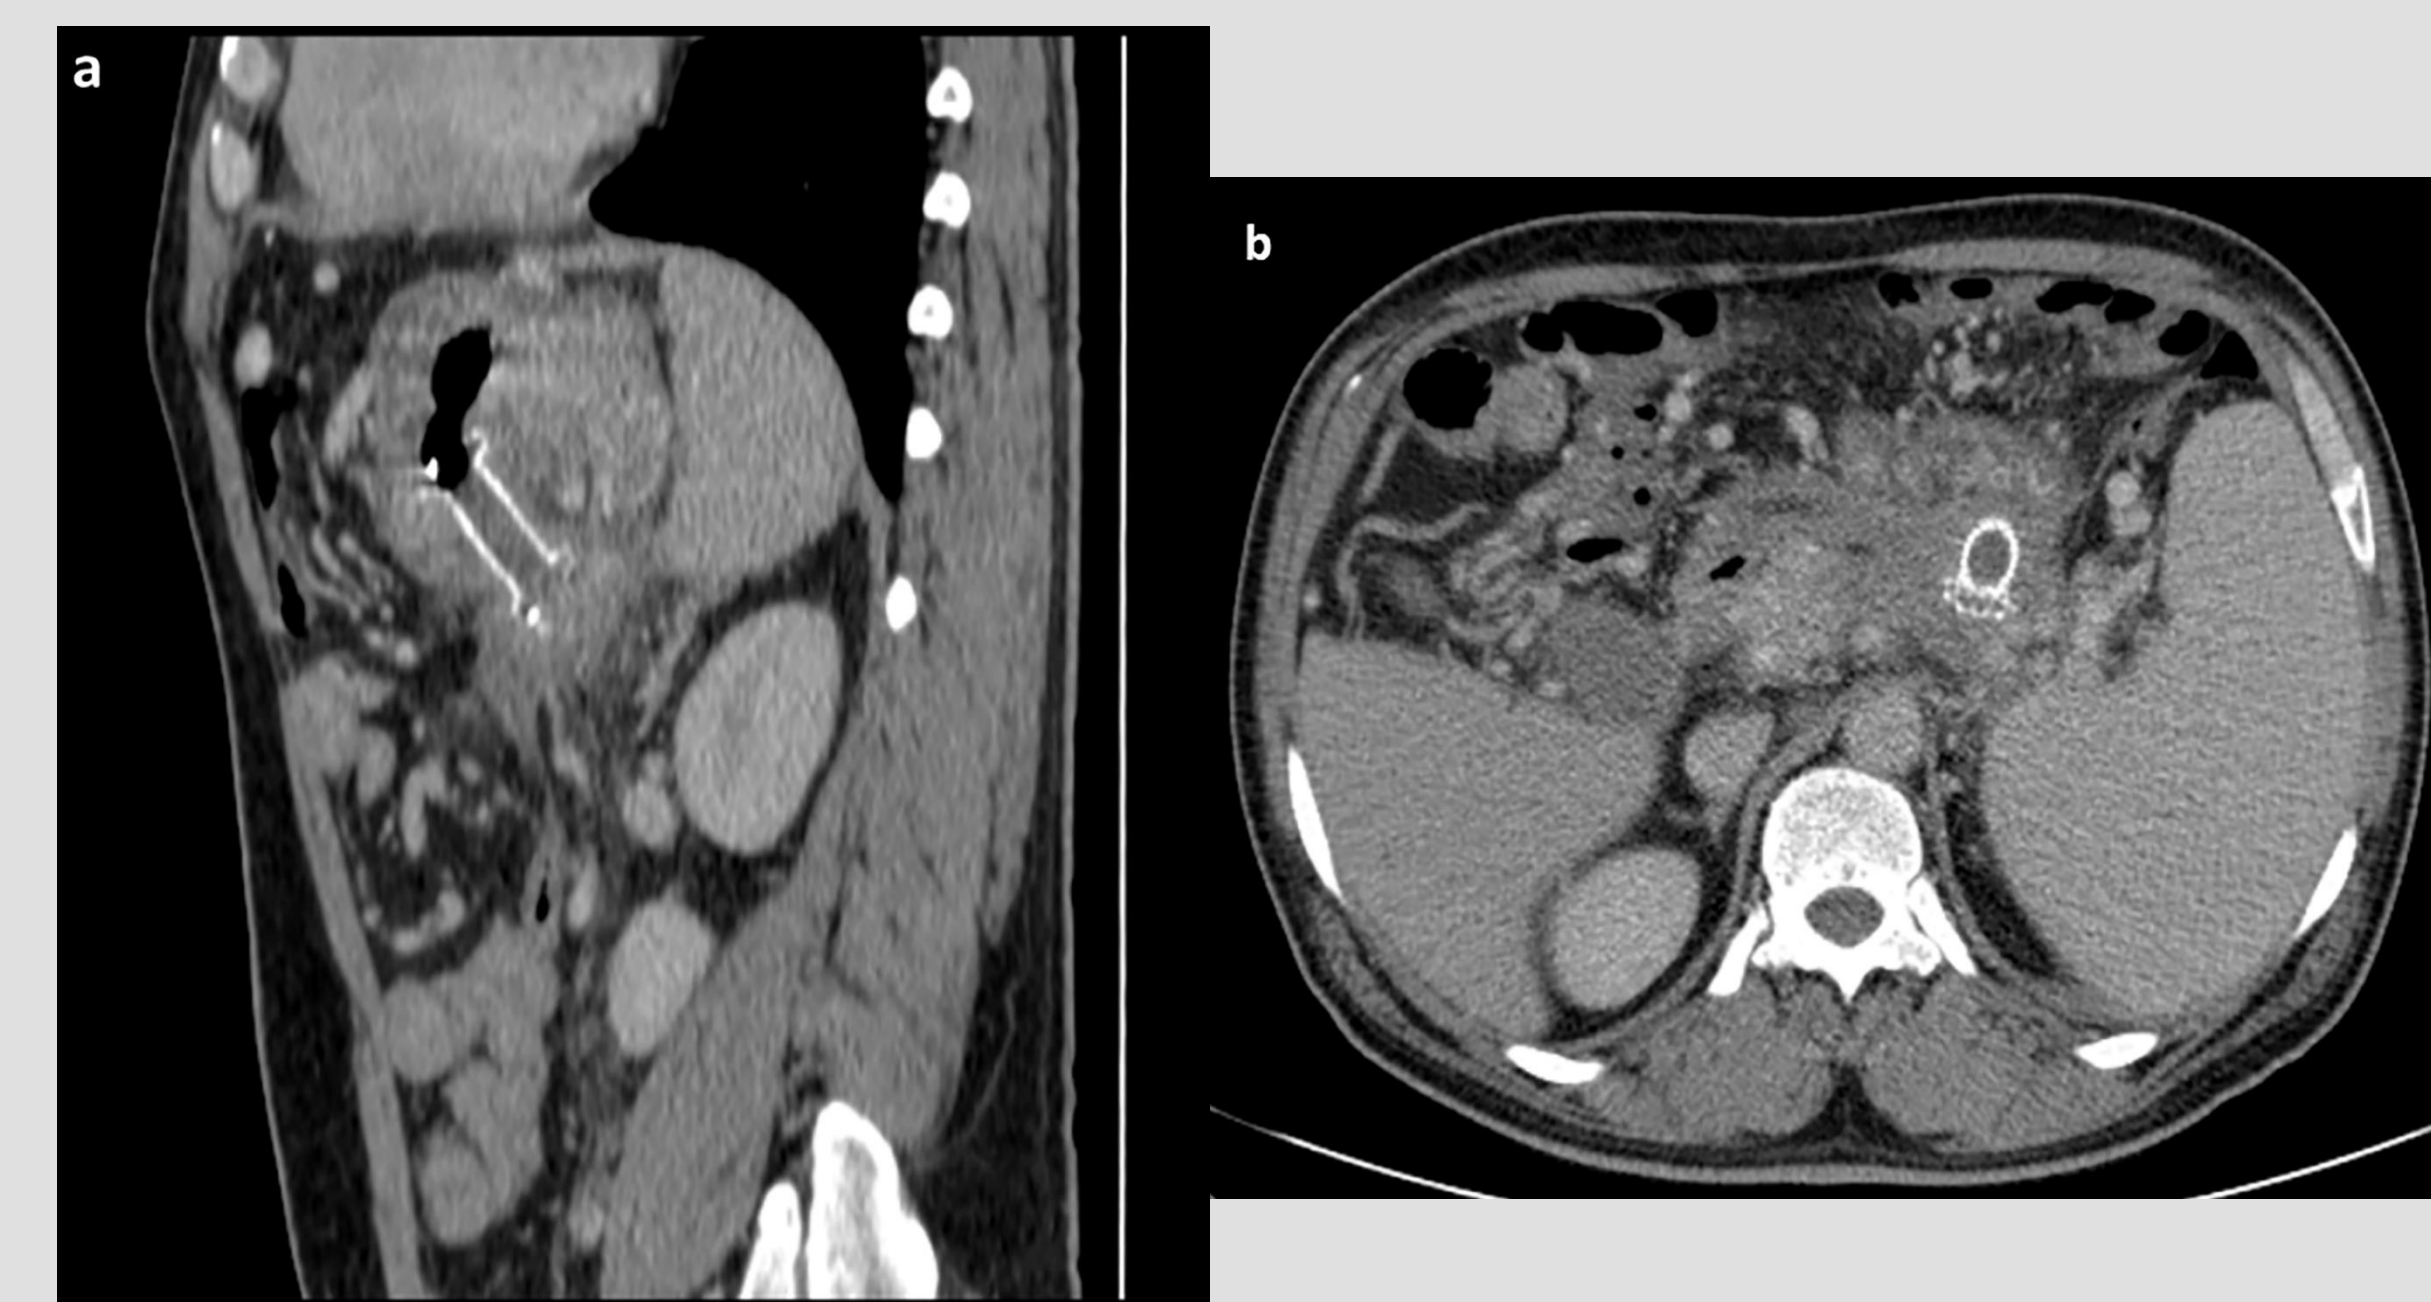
Abdominal CT scan, in coronal view (a), showing a correctly positioned fully covered double-flanged metal stent and, in axial view (b), showing complete resolution of the pancreatic pseudocyst
